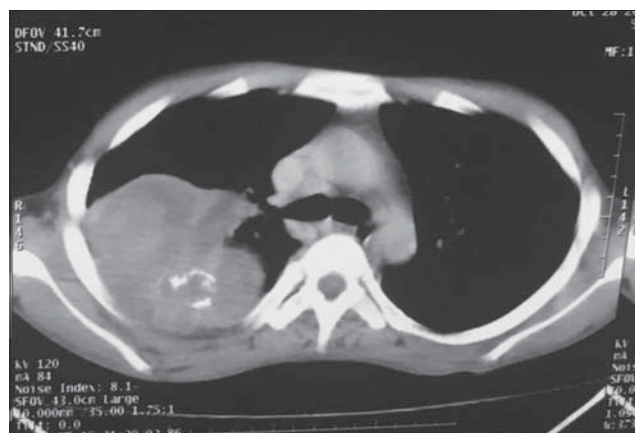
Contrast-enhanced computed tomography of the thorax in mediastinal window depicting speculated intrathoracic mass in the right upper zone
